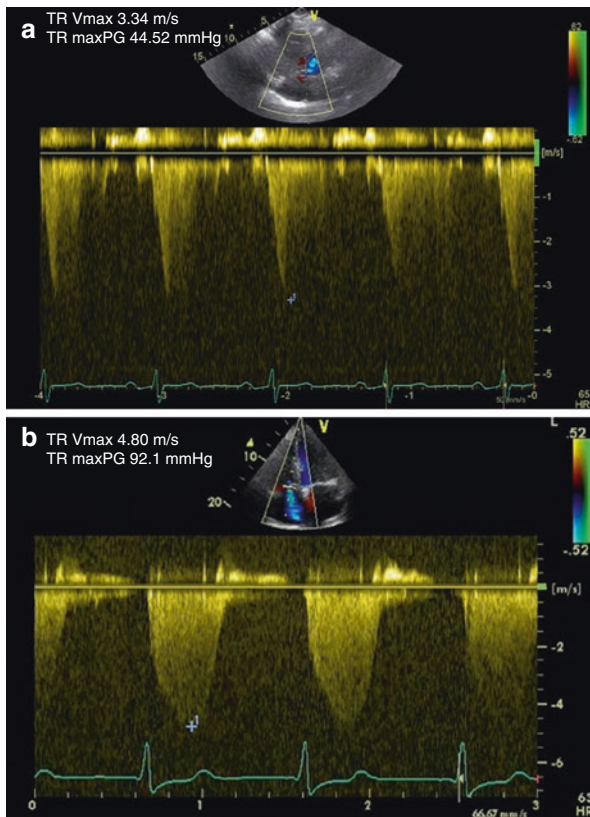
(a) Continuous wave Doppler regurgitation velocity of the tricuspid valve. (b) Continuous wave Doppler regurgitation of the tricuspid valve of another pulmonary hypertension patient
